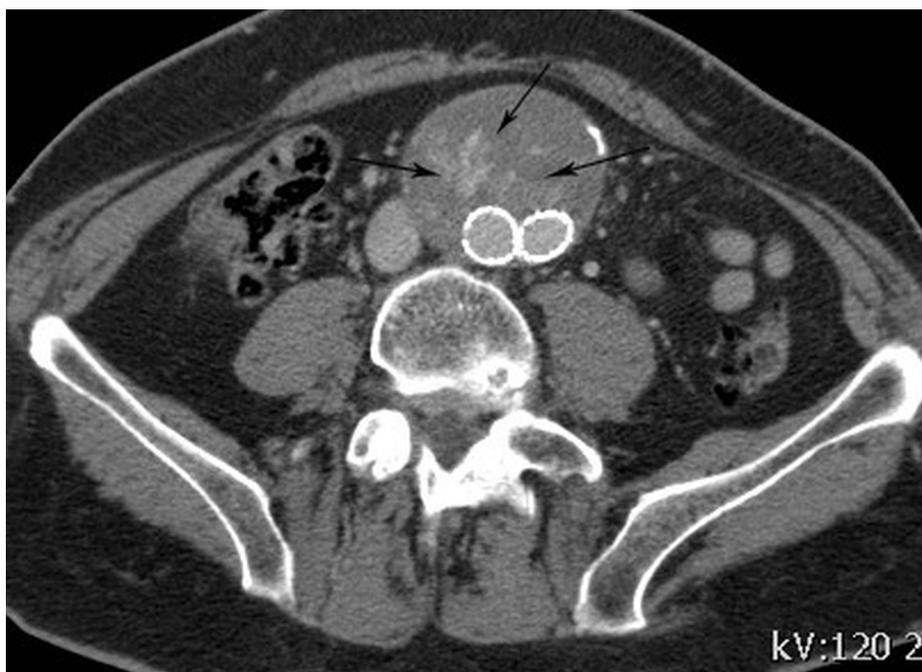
Venous phase, contrast-enhanced axial computed tomography image in a patient with a growing aneurysm sac and an unsharply delineated type 2 endoleak (small black arrows) anterior to the endograft limbs.
